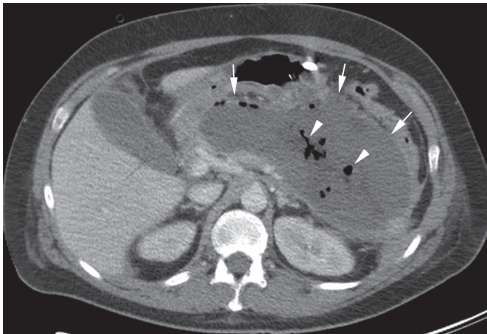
A 51-year-old woman with infected necrosis. Contrast-enhanced CT performed on day 26 after symptom onset shows a nearly completely encapsulated necrotic collection (arrows) with impacted gas bubbles (arrowheads), virtually diagnostic for infection of necrosis.
